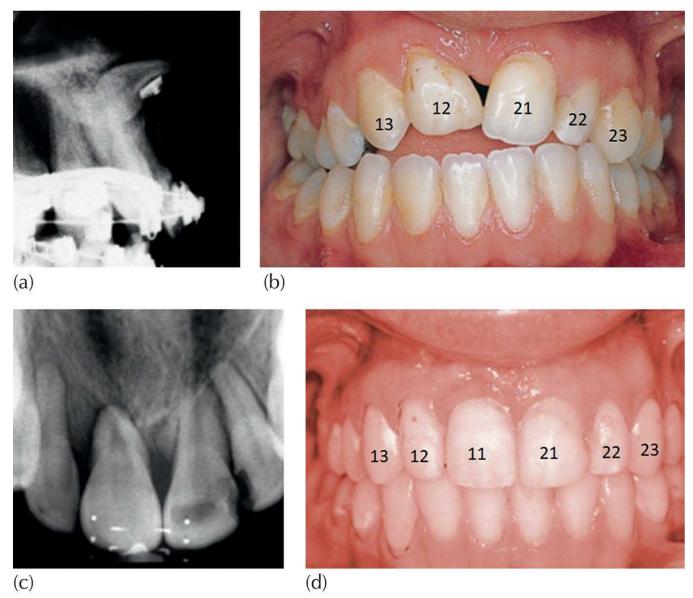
The location of the dilacerate central incisor in a 24-year-old patient. (a) Tangential radiographic view of the dilacerate incisor. (b) The attempt at treating the lateral incisor by prosthodontic enlargement and reshaping. (c) The periapical radiograph of the dilacerate incisor, re-aligned by orthodontic treatment. (d) Intra-oral view of the resolved incisor impaction following orthodontic treatment and surgical exposure.
